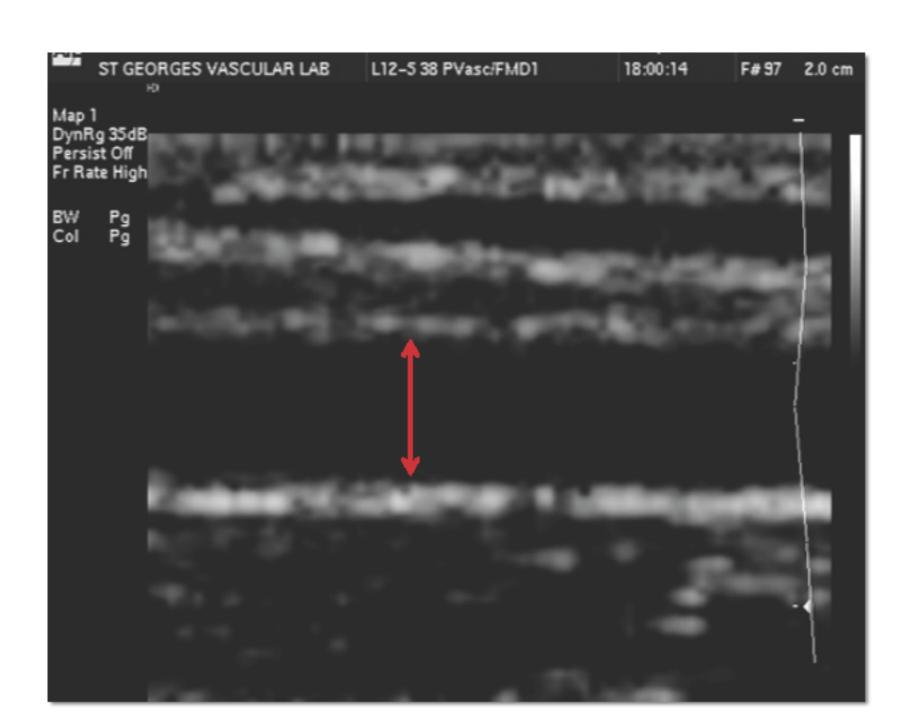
A longitudinal ultrasound image of the brachial artery. The red arrow shows the diameter.
